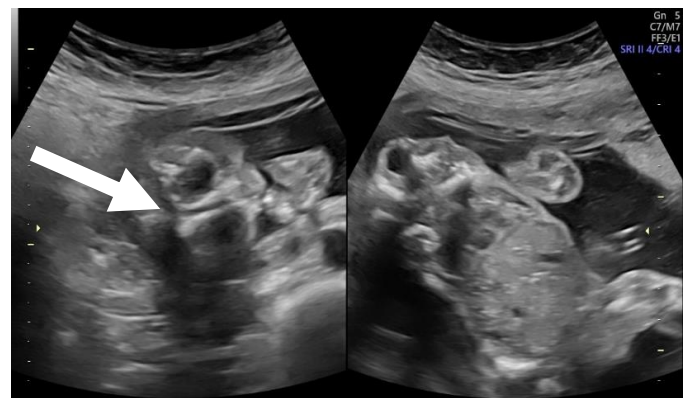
ultrasonography evaluation at 19 weeks gestation. White arrow showed the cerebellum outside the cranium
